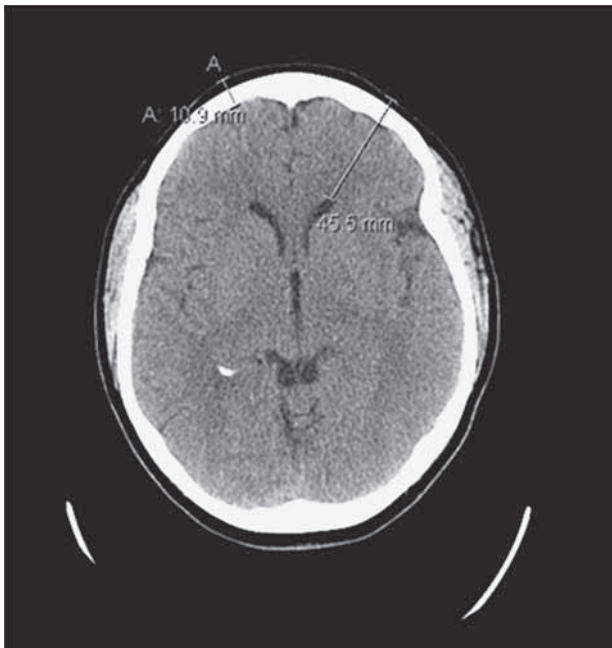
CT scan of a 66-year-old female head. The collective thickness of skull and scalp is 10.9 mm in the forehead region and the distance from skin to ventricle deep in brain is 45.5 mm.
